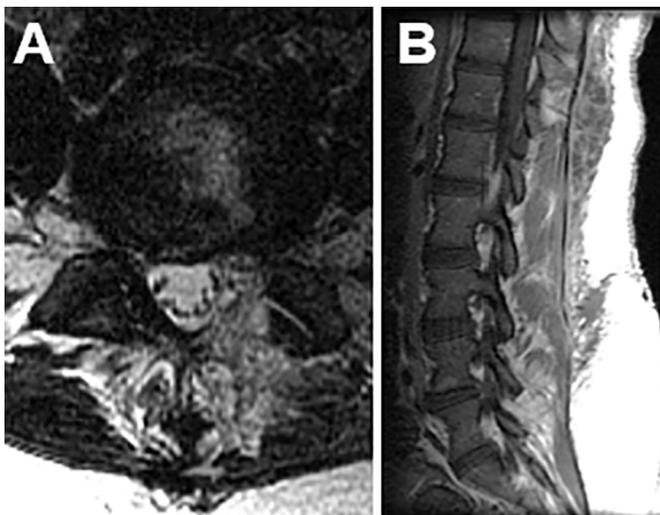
Post-laminectomy and microdiscectomy MRI with routine post-operative changes.
